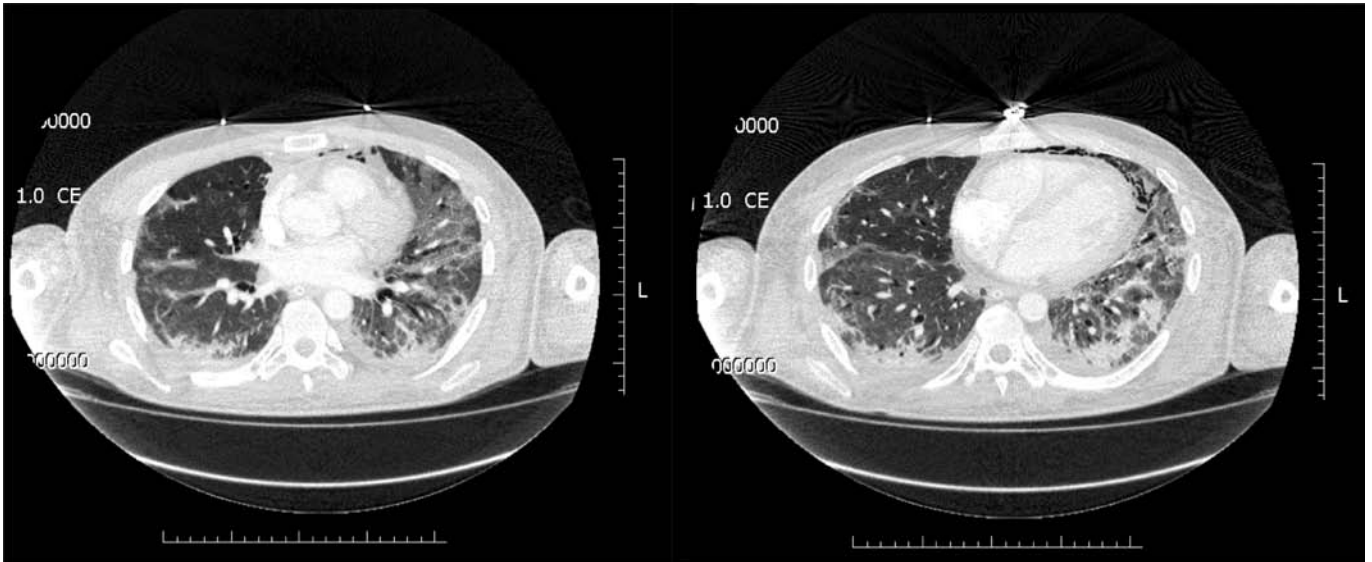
Thoracic computed tomography following completion of pulse therapy. Bilateral pulmonary "ground glass" opacities predominantly affecting the lingula of the left lung with considerable reduction compared to the previous exam. Consolidated pulmonary opacities in the posterior and lateral basal segments of the lower lobes with pneumomediastinum and bilateral small pleural effusion.
